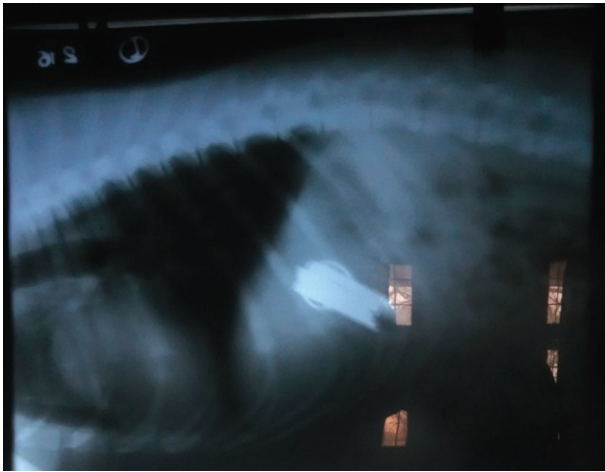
Radiograph showing opaque object suggestive of metallic foreign body in stomach.
